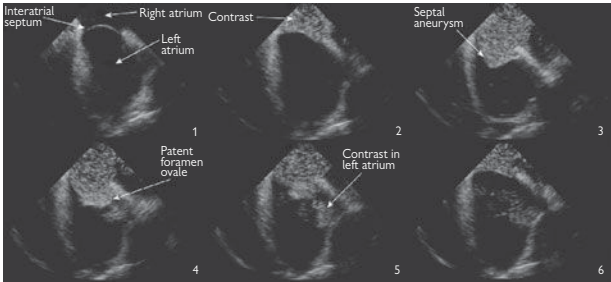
Intracardiac echocardiogram demonstrating passage of agitated saline contrast from the RA through a PFO into the LA. The interatrial septum is aneurysmal.
